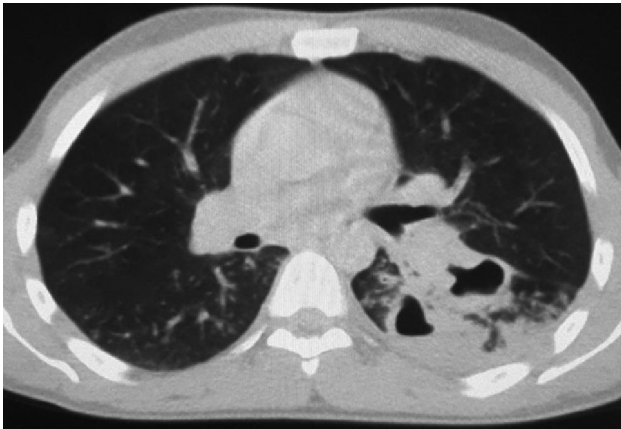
HRCT Chest, lung window, axial section at the level of subcarina reveals two cavitating lesions with thick walls and surrounding alveolar infiltrates in superior segment of lower lobe of left lung. Associated pleural and fissural thickening also appreciated. Few tree-in-bud opacities are demonstrated in superior segment of lower lobe of right lung as well.
